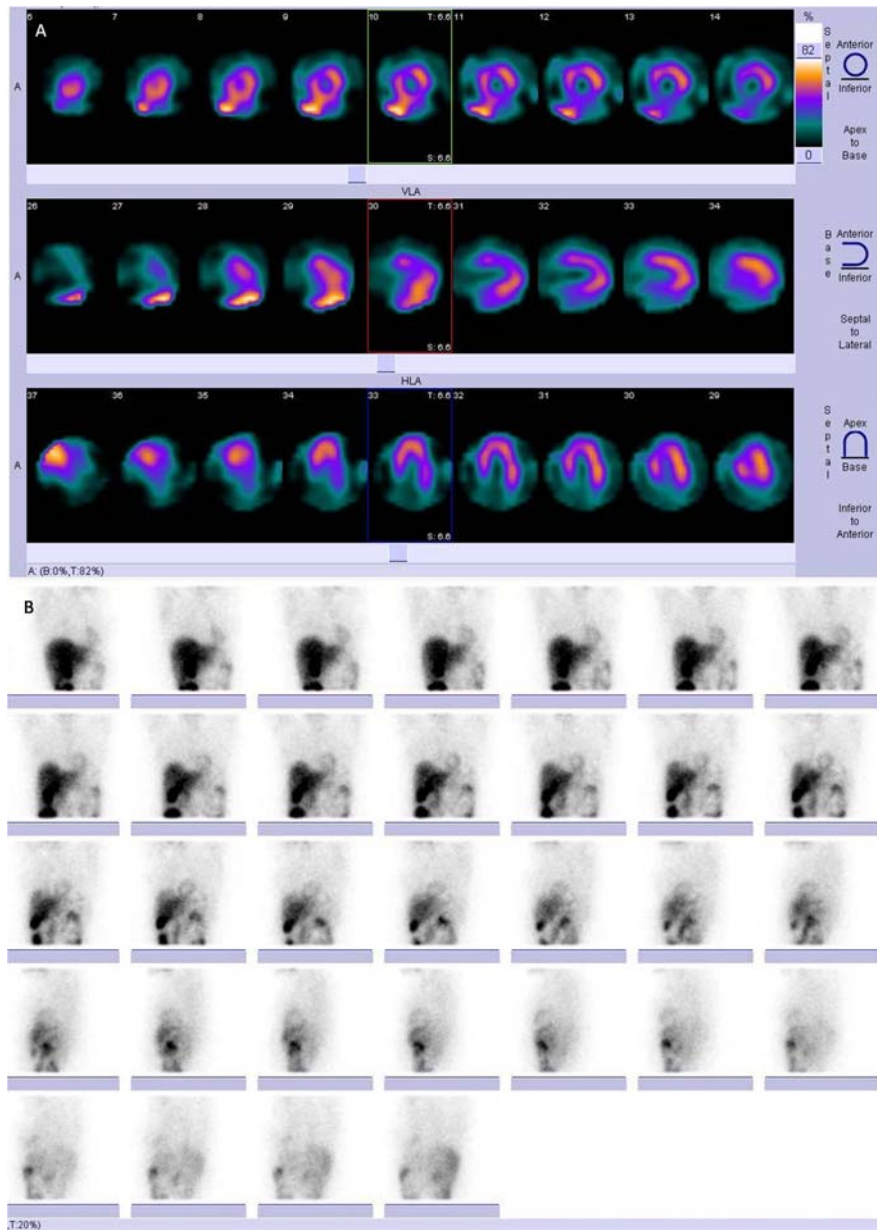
Processed images (A) and raw projections (B) of 60 min SPECT of the patient.
